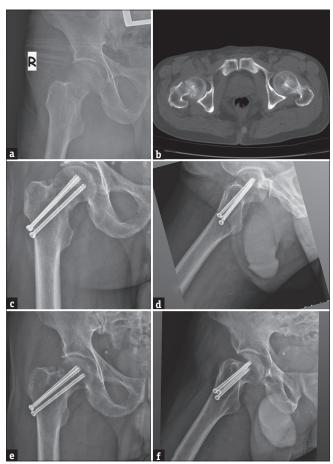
(a) A 36-year-old man sustained femoral neck fracture after a sports injury. (b) axial view on preoperative computed tomography. (c) and (d) early postoperative X-ray after closed reduction and internal fixation. (e and f) sixth months postoperative X-ray
